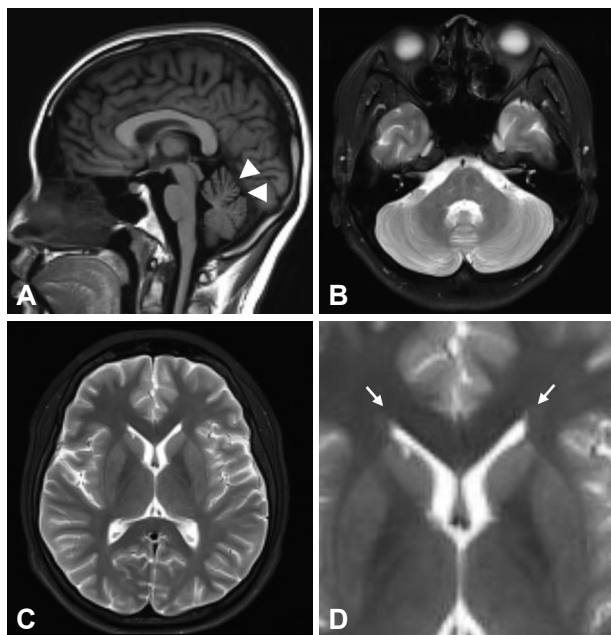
Sagittal T1-weighted imaging showed no atrophy in the corpus callosum, but mild cerebellar atrophy was observed in the upper part of the anterior and posterior lobes (A, arrow heads). An axial T2-weighted scan exhibited a cruciform T2-weighted hyperintensity in the ventral pons (B) and flame-shaped hyperintensities at the tips of the frontal horns of the lateral ventricles (C and D, arrows).
